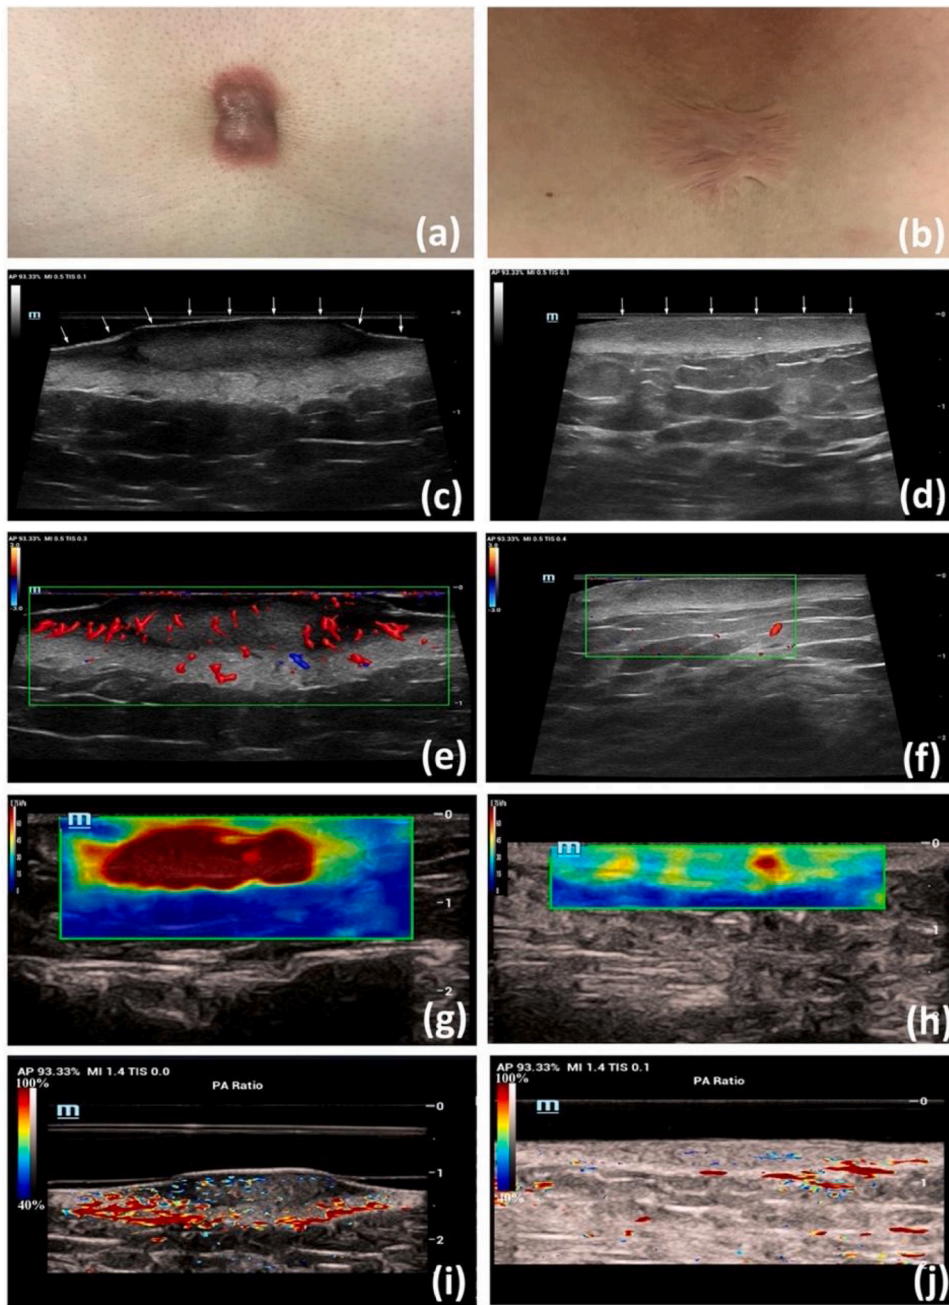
A typical active keloid and an inactive keloid were compared. (a) Color image of an active keloid: It was thick and pigmented. (b) Color image of an inactive keloid: It was flat, and the color was almost normal. (c) GSUS image of an active keloid (white arrow): It was markedly hypoechoic. (d) GSUS image of an inactive keloid (white arrow): It was isoechoic. (e) UMA image of an active keloid: The blood flow grading was with high presence of vessels. (f) UMA image of an inactive keloid: The blood flow grading was with almost no presence of vessels. (g) Elastography of an active keloid: It was extremely hard. (h) Elastography of an inactive keloid. (i) PA image of an active keloid showed abundant PA signals, indicating more vasculature. (j) PA image of an inactive keloid showed sporadic PA signals, indicating less vasculature. GSUS: gray scale ultrasonography, UMA: ultra-micro-angiography, PA: photoacoustic.
